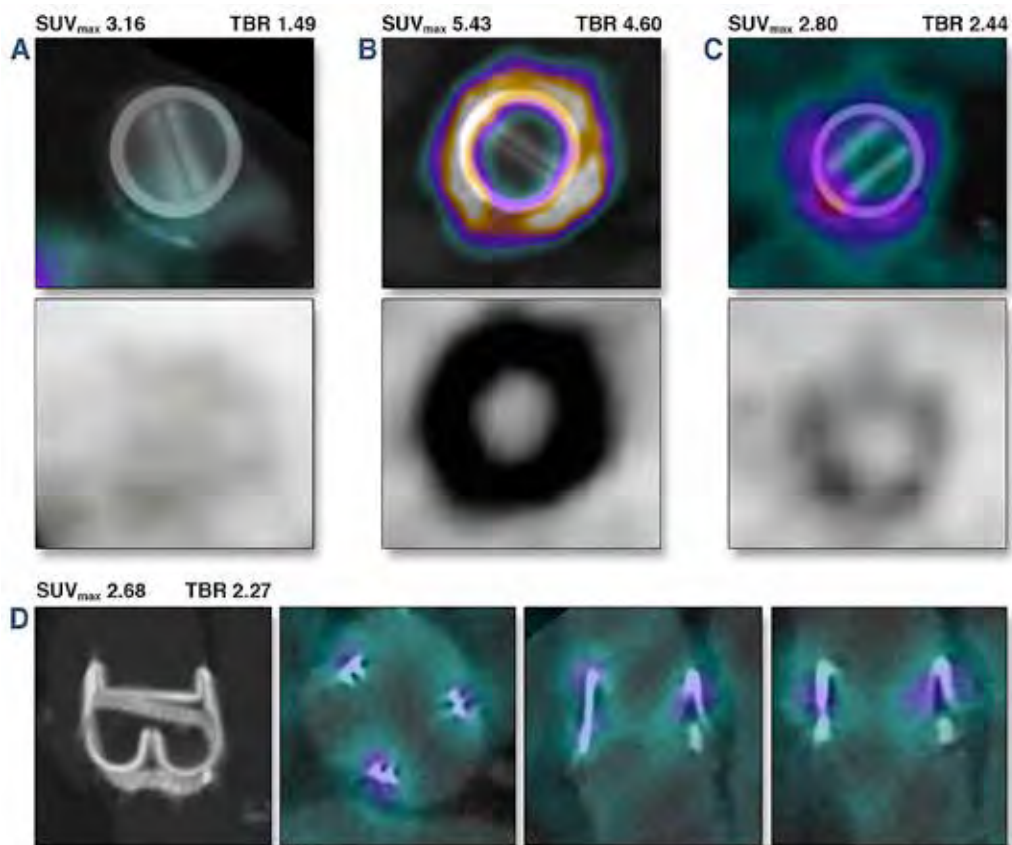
^{18}F -FDG PET/CT in PHV endocarditis: how much is too much? PET/CT images of the valvular plane in 3 different patients with a mechanical prosthetic heart valve (PHV) (A-C) and a patient with a Carpentier-Edwards bioprosthesis (Edwards Lifesciences, Irvine, California), with maximum standard uptake values (SUV_{max}) and target-to-background ratios (TBR) (SUV_{max} PHV divided by SUV_{mean} aortic blood pool). (A) Images show no significant ^{18}F -FDG uptake surrounding the PHV in a patient without endocarditis. (B) Images show intense uptake of ^{18}F -FDG in surgically confirmed infection of the aortic root surrounding the PHV ring. (C) Images show mild to moderate uptake of ^{18}F -FDG surrounding and confined to the PHV ring, in a patient confirmed by follow-up to have no PHV endocarditis. (D) Images show mild, symmetrical ^{18}F -FDG uptake at or near the struts to which the leaflets are fastened (shown in detail in the first CT–maximum intensity projection image), typical of this type of prosthesis. A mild to moderate amount of ^{18}F -FDG uptake around a PHV is a normal variant, possibly due to a mild foreign body reaction or strain on the aortic wall.
